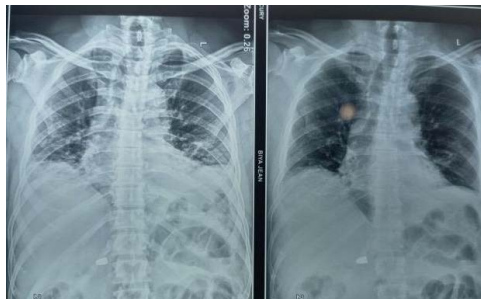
Frontal thoraco-abdominal x-ray.
